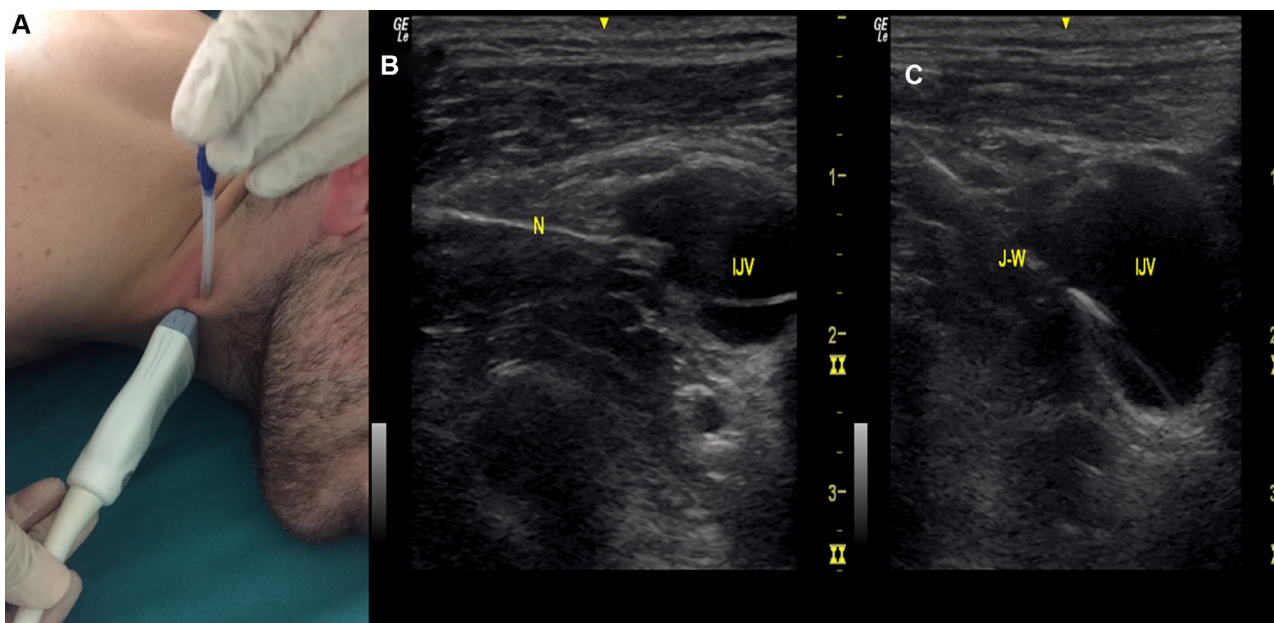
(A) The lateral-medial oblique approach for ultrasound-guided internal jugular vein cannulation (mannequin). (B) Short-axis view (internal jugular vein), in-plane technique (needle). (C) The J-tip guide wire within the internal jugular vein. IJV, internal jugular vein; J-W, J-tip guide wire; N, needle.
